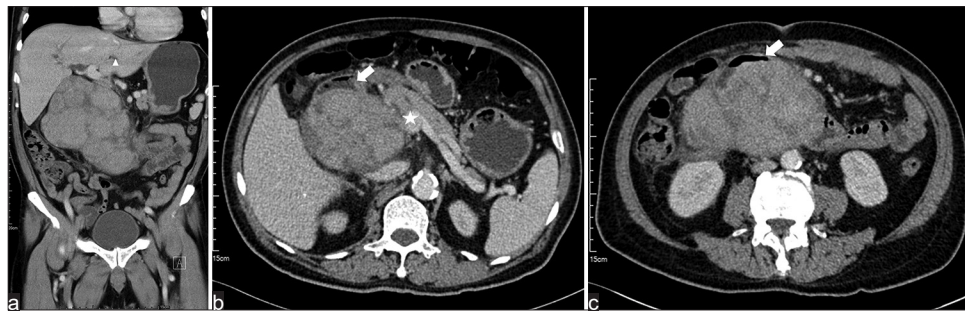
(a) A whole abdominal computed tomography that identified a large heterogeneous multi-lobular retroperitoneal tumor, about 17 cm in size, in the duodenal lumen; mass effect caused a dilated intrahepatic duct (white triangle). (b) Dilated pancreatic duct dilatation (white star); (b and c) and flattened duodenum (white arrow)
